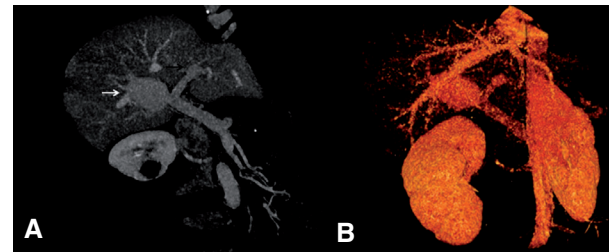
Coronal reformation MIP (A) and 3D volume rendering (B) CT images show portal vein aneurysms of the right (white arrow) and left (black arrow) branches of the portal vein.
